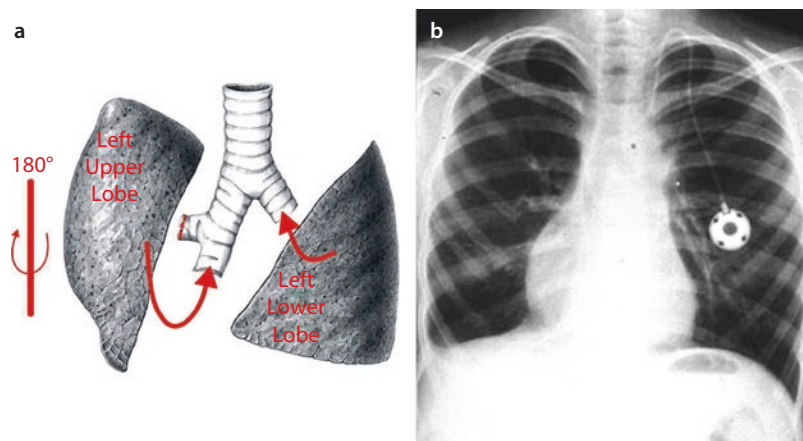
a Technique of split lung transplantation and b typical postoperative chest X-ray (From Marta et al. 2005. Used with permission)
